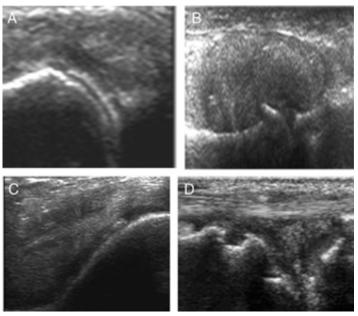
A. double contour sign in gout; B. A gouty tophus sonographically. Intra-cartilage linear (C) and meniscal (D) hyperechoic deposit of CPPD.
